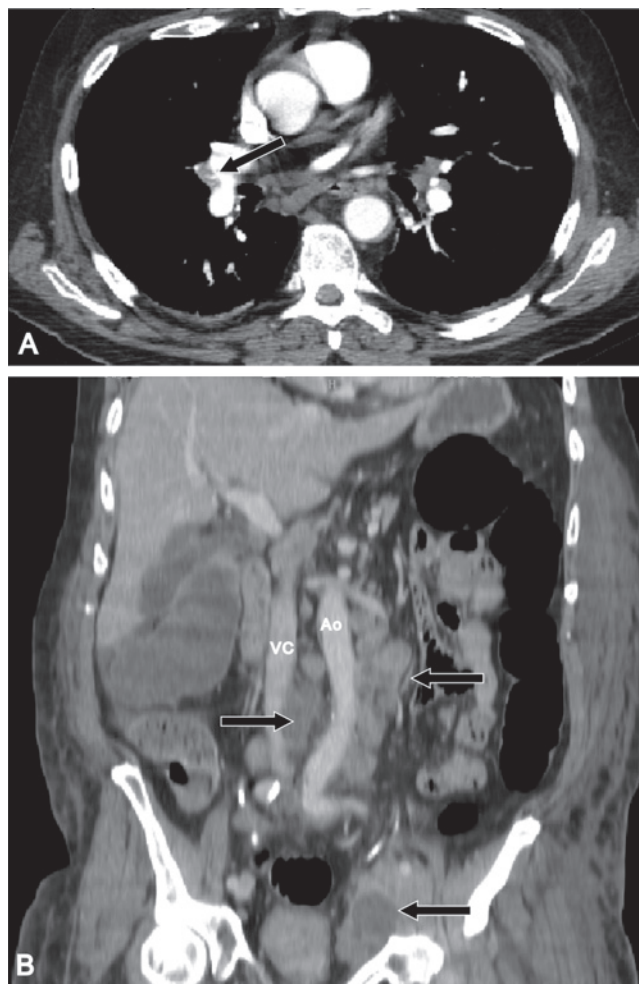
Initial CT scan of the chest, abdomen, and pelvis of a 65-year-old male with chronic low back pain who presented with left lower extremity phlegmasia cerulea dolens. The chest CT (A) shows an asymptomatic pulmonary embolus (arrow). The abdominal CT (B) shows extensive retroperitoneal and pelvic lymphadenopathy (arrows) compressing the distal vena cava and the left iliac system. All patients presenting with iliofemoral DVT by duplex ultrasound receive chest, abdominal, and pelvic CT scans as part of the initial workup.
